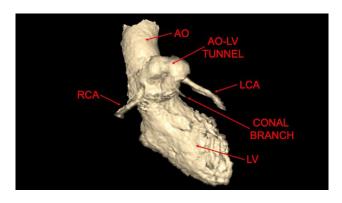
Three dimensional computed tomography reconstruction. This procedure enhanced clarification of the relationship between the tunnel and coronary arteries prior to intervention. Abbreviations: AO, aortic valve; LV, left ventricle; RCA, right coronary artery; LCA, left coronary artery.
